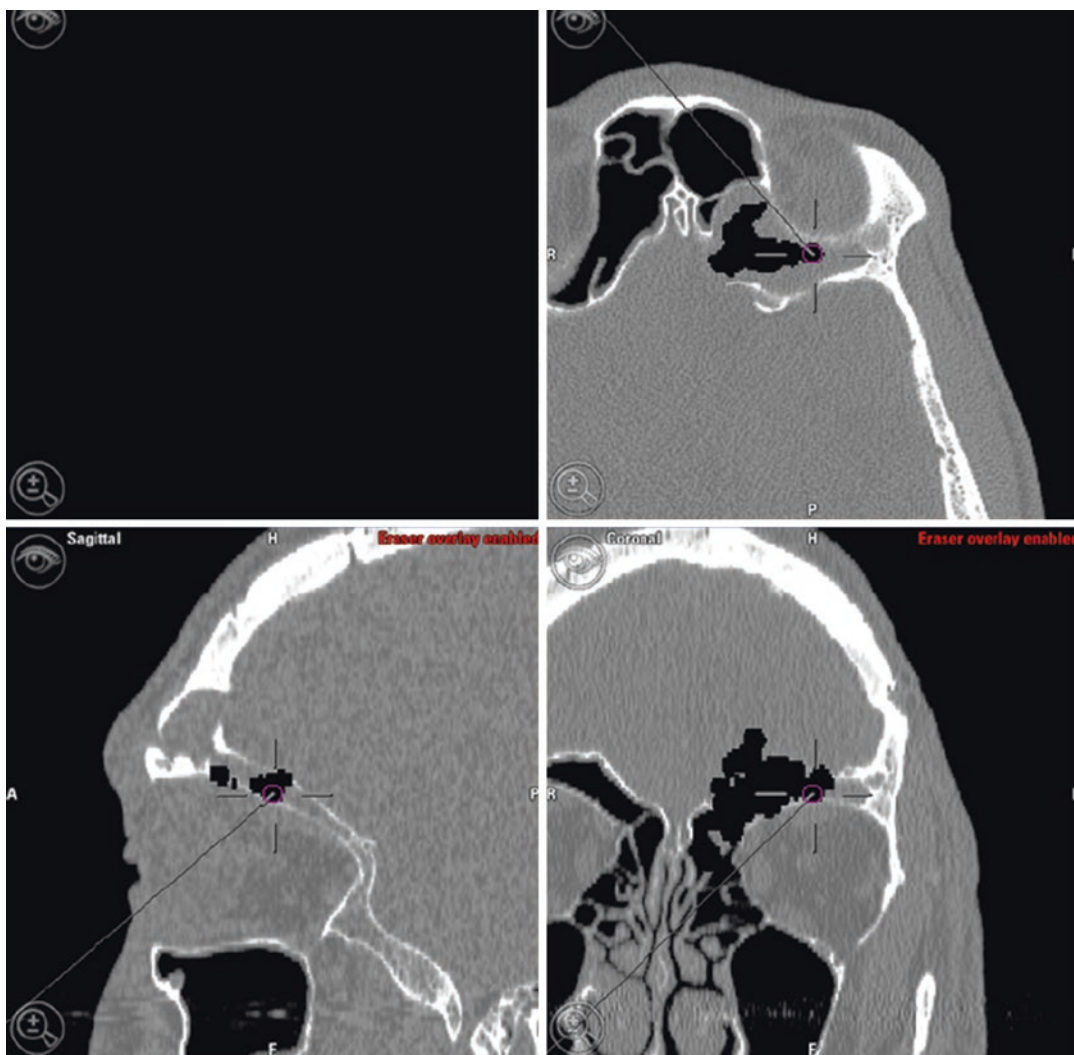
An intraoperative endoscopic view with triplanar CT imaging of a patient with a left supraorbital ethmoid mucocoele and corresponding skull base erosion
